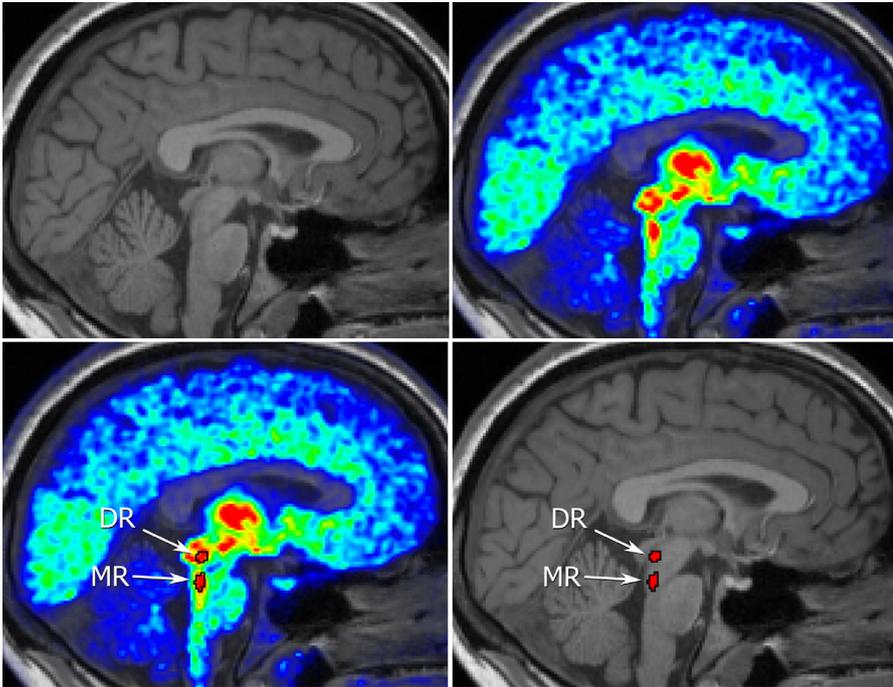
(A) Structural MRI image, where the dorsal and median raphe (DR and MR) nuclei are not identifiable. (B) $[^{11}\text{C}]\text{DASB}$ PET image superimposed on the corresponding structural image, highlighting the 5-HTT system. The raphe nuclei are visible within brainstem as regions of higher binding. (C) Delineation of the DR and MR nuclei based on $[^{11}\text{C}]\text{DASB}$ PET. (D) DR and MR identified from the $[^{11}\text{C}]\text{DASB}$ PET image transferred as seeds onto the structural image. Figure from [3], Copyright © 2015 Elsevier Inc.
